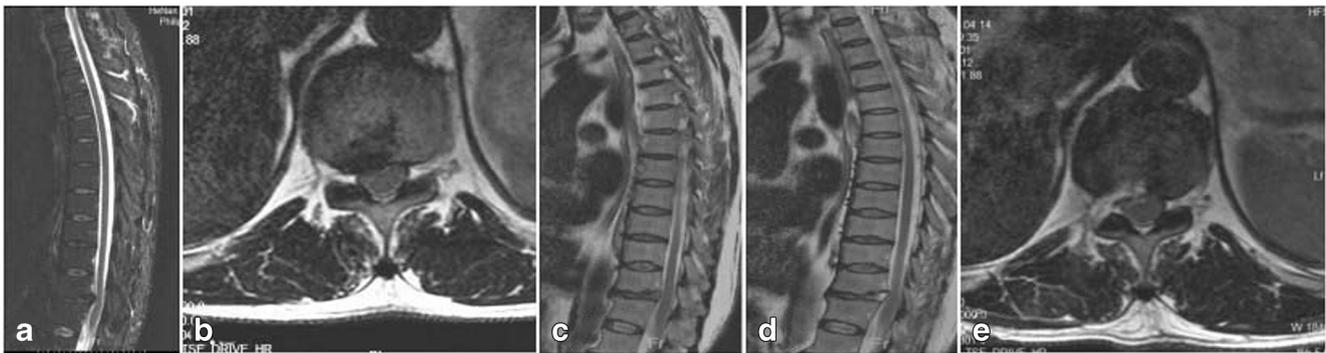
Pre-operative MRI (a, b) of the thoracic spinal cord in the sagittal and sectional section; T2-weighted sequence showed spinal cord compression by herniated disc at T11/12. Both the sagittal (c, d) and axial
